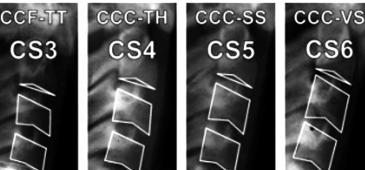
Morphological appearance and related tips of cervical spine radiograph.
